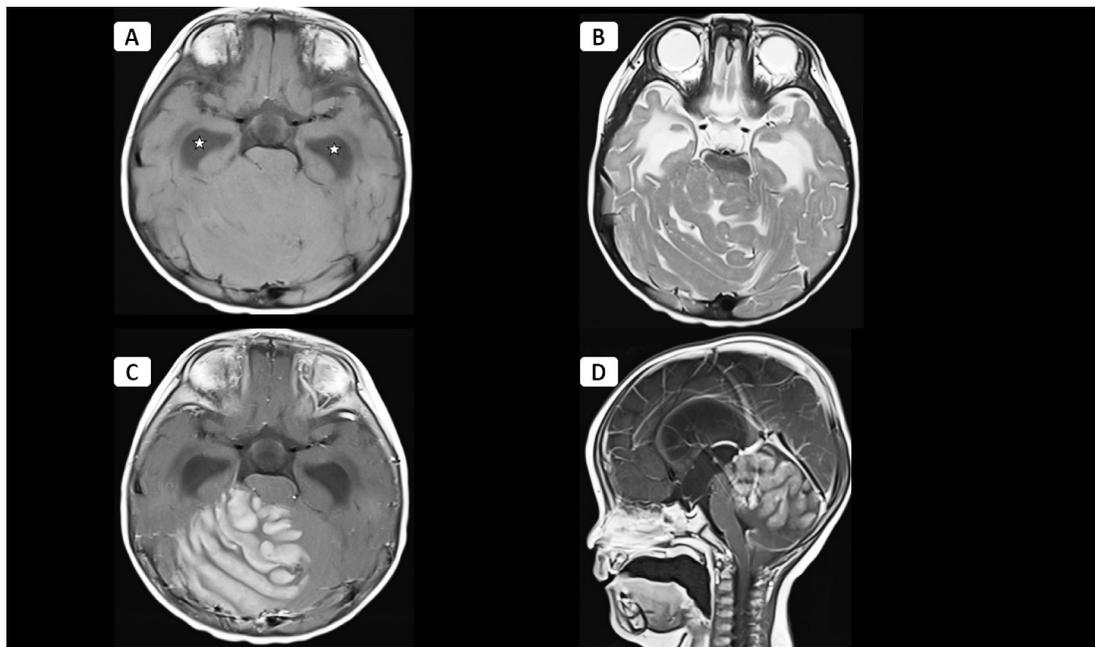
MRI brain images in pre-contrast axial T1W (A), axial T2W (B), post-contrast axial (C) and sagittal (D) T1W sequences showed a mass at midline posterior fossa occupying the right cerebellum. The mass is isointense on pre-contrast T1W (A), hypointense with grape-like nodular appearance on T2W (B) and avid nodular enhancement on post-contrast axial (C) and sagittal (D) T1W images. There was mass effect and bilateral lateral ventricles (star) hydrocephalus due to outlet obstruction at the level of fourth ventricle.
